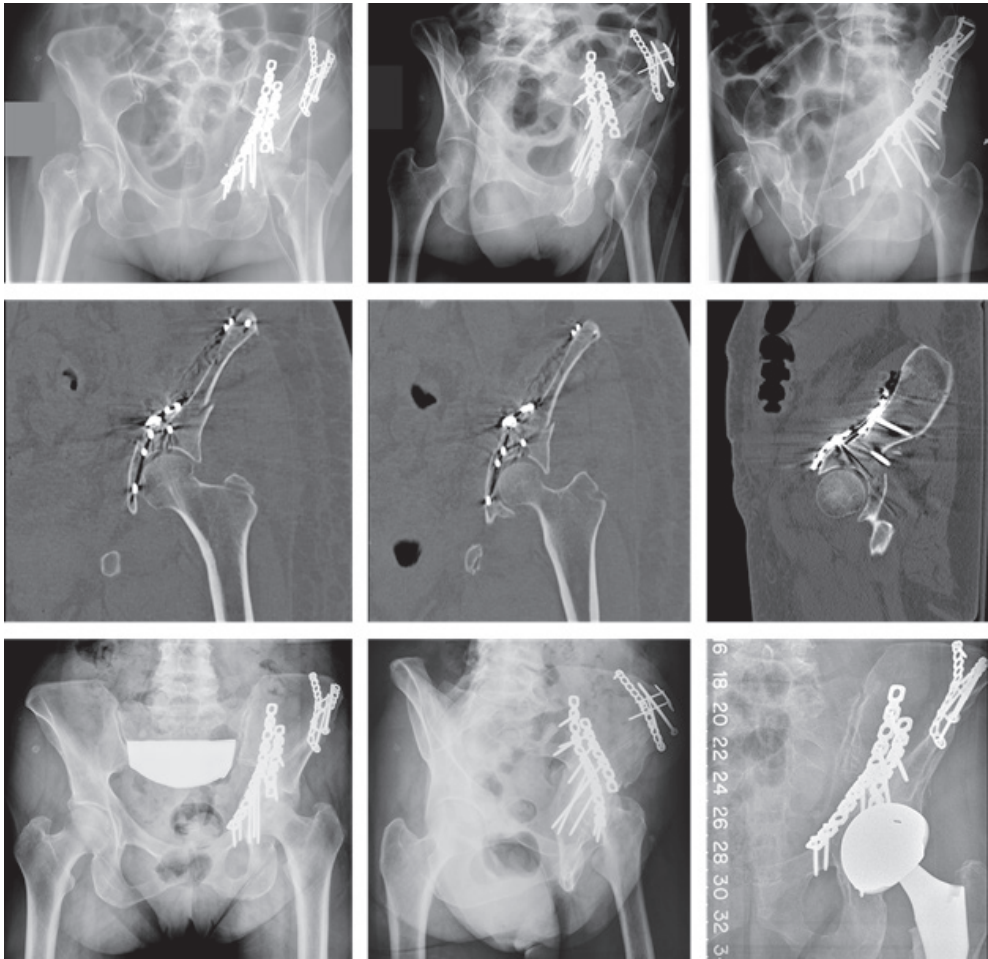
Postoperative images of a 61-year-old woman treated for an anterior column-posterior hemitransverse acetabular fracture. Radiographs appeared to show anatomic reduction (top row). However, CT revealed poor reduction (middle row). The patient developed posttraumatic arthritis and ultimately required THA (bottom row).
